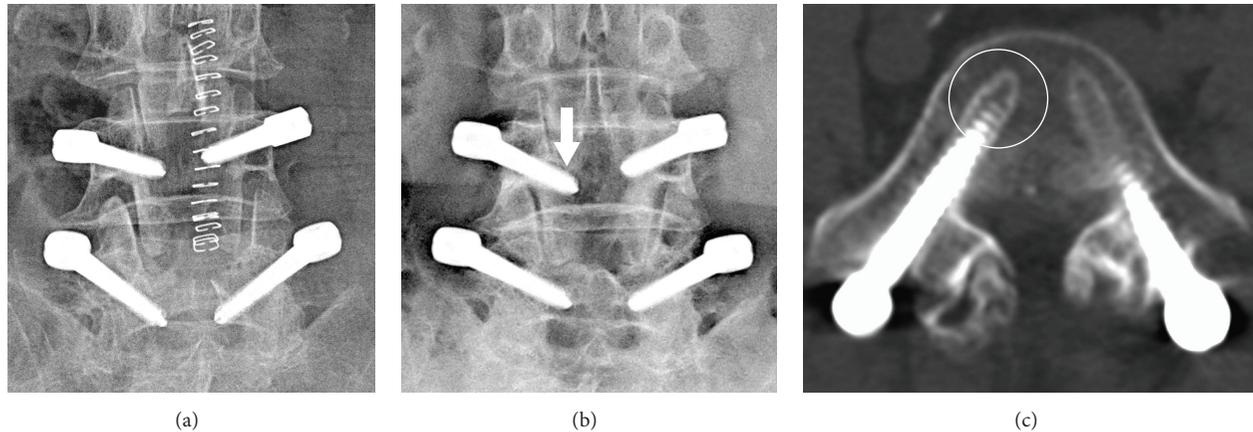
Postoperative images obtained from a 69-year-old female patient who underwent dynamic stabilization at the level of L4/5. (a) Plain radiograph on postoperative day 3. (b) Postoperative plain radiograph 6 months after surgery documented the halo sign (arrow) which was indicative of screw loosening. (c) CT scan performed 19 months after surgery documented the presence of screw loosening (circle).
